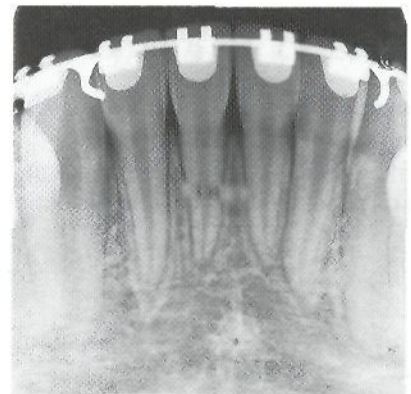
Intra-oral radiographs showing parallel lower incisor roots in the case featured in the adjacent photograph.
